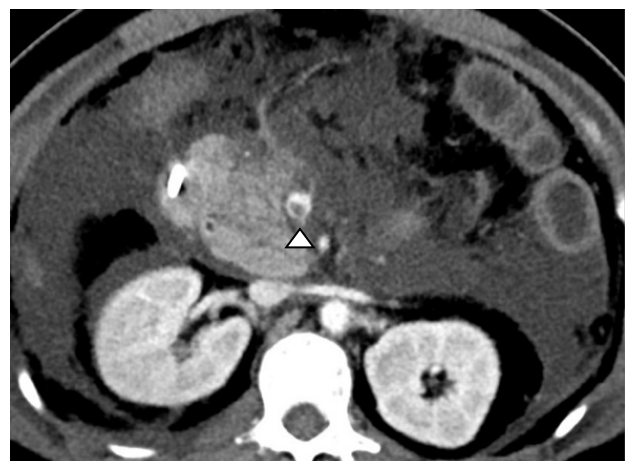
Abdominal contrast-enhanced CT imaging at presentation showing a nonocclusive thrombus in the superior mesenteric vein (arrowhead).
